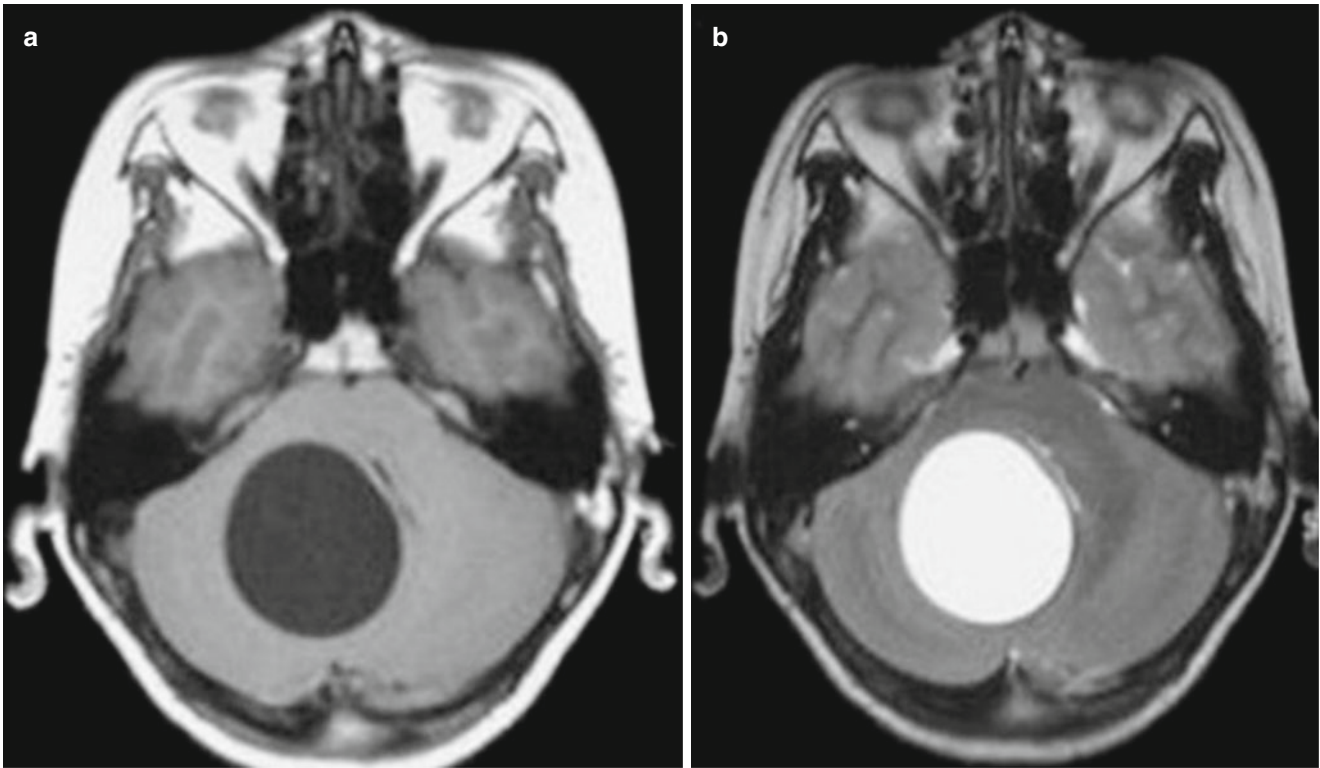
Cerebral cystic echinococcosis. (a, b) MR imaging demonstrates cystic space-occupying lesion in the cerebellum with watery density, well-defined boundary, and intact capsule
